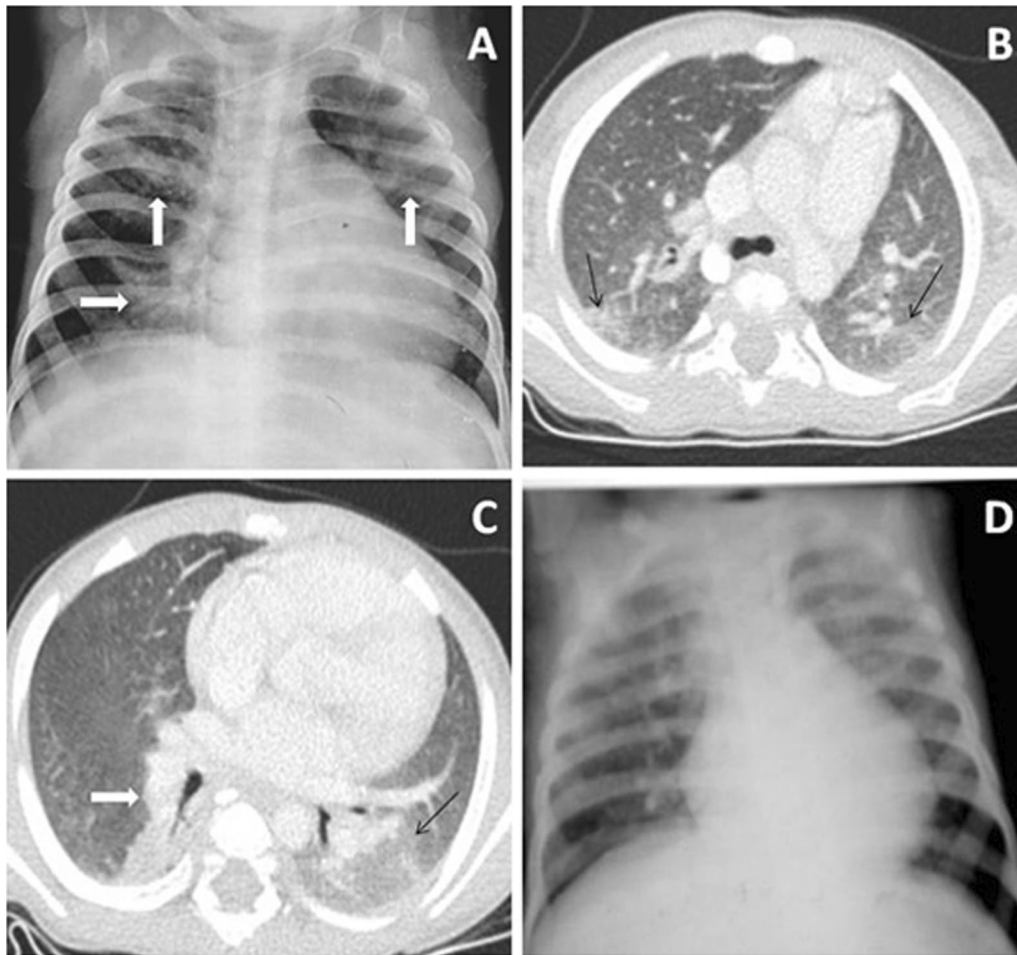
Fungal Infection. Frontal CXR in an 18-month-old HIV-positive male child, presented with recurrent episodes of cough & fever for last 3 weeks, reveals inhomogeneous nodular opacities involving bilateral upper lung and right lower zone (arrows, A). CECT chest (axial, lung window) showed GGO in posterior part of bilateral upper lobes & posterior basal segment of LLL (black arrows in B,C), and dense consolidation involving apical, medial basal and posterior basal segments of RLL (white arrow, C). CD4 count was 172 cells/mm³. Neutrophil count was 20%. BAL isolated *Pneumocystis jiroveci* and *Candida* species. Serial follow-up radiographs showed persistence of findings (D). Patient soon expired
